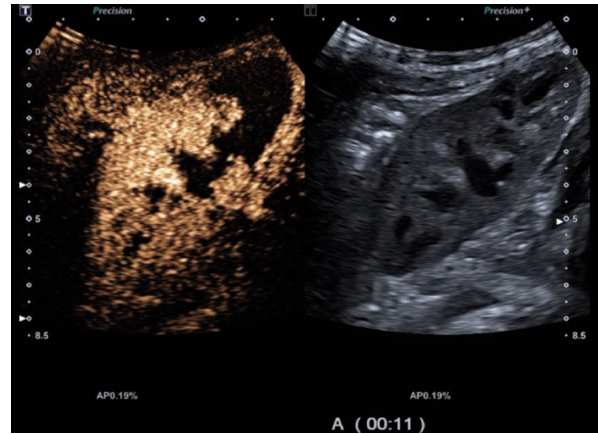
Patient B with suspected perfusion impairment in the transplanted kidney in Doppler ultrasound – CEUS performed at 11 seconds after intravenous UCA administration revealed an absence of contrast enhancement in the entire lower pole of the graft (visible as a black area), indicating ischemia in this region. The grayscale US image of the graft (right) did not show any visible focal lesions
